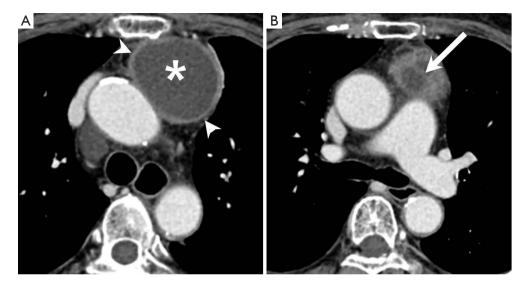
CT scans reveal a well-defined cystic lesion (asterisk in A) with an enhanced wall (arrowheads in A) in the left prevascular mediastinum. A small septum is suspected at the inferior portion of the cystic mass (arrow in B). CT, computed tomography.
